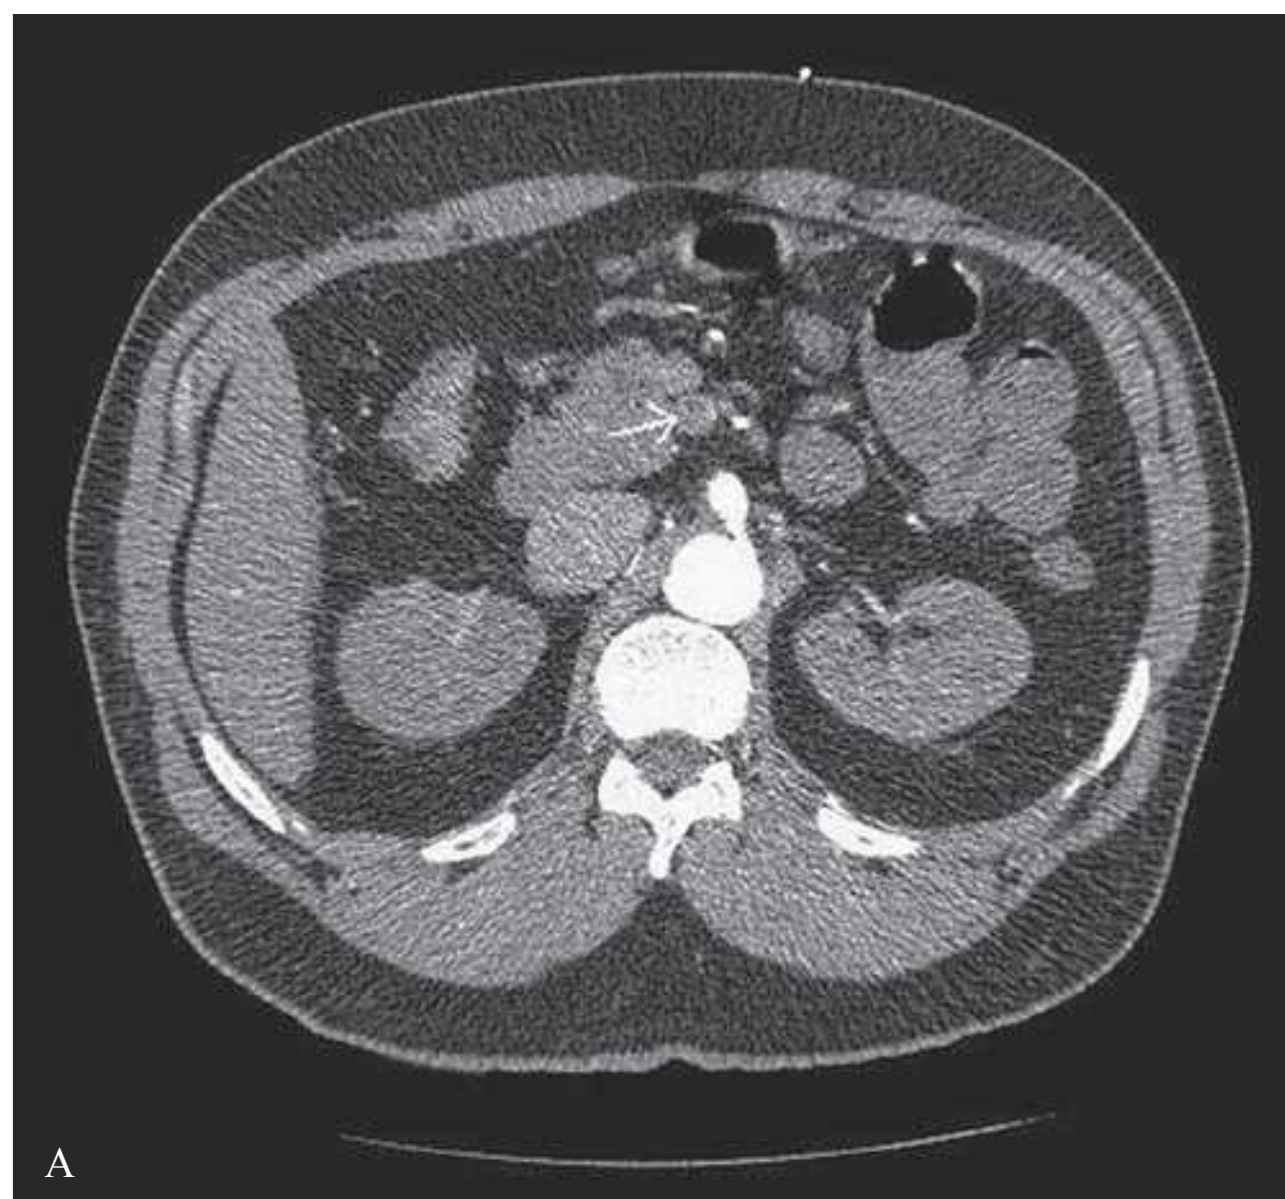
CTA of patient with mesenteric occlusion axial (A), 3D reconstruction (B).
